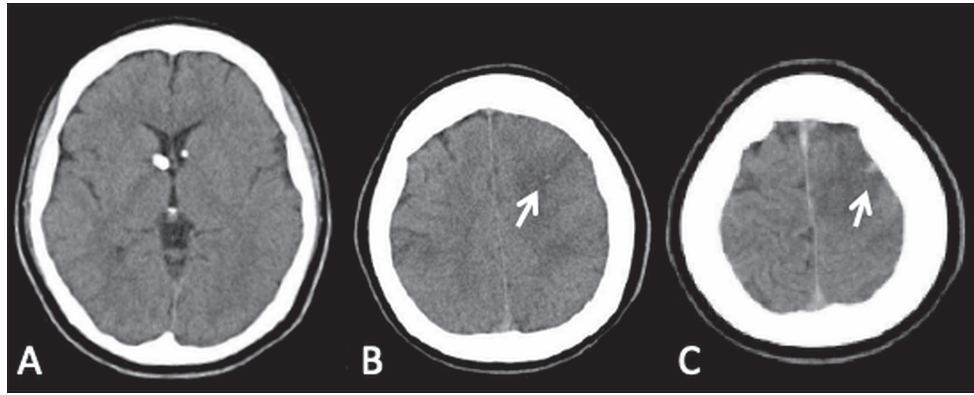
Brain computed tomography on admission demonstrates bilateral subependymal nodules and at caudate nucleus that are calcified (A) and bilateral frontal edema with a very small area of hyperdensity in the left frontal region (B, C) as congestion (arrows).
